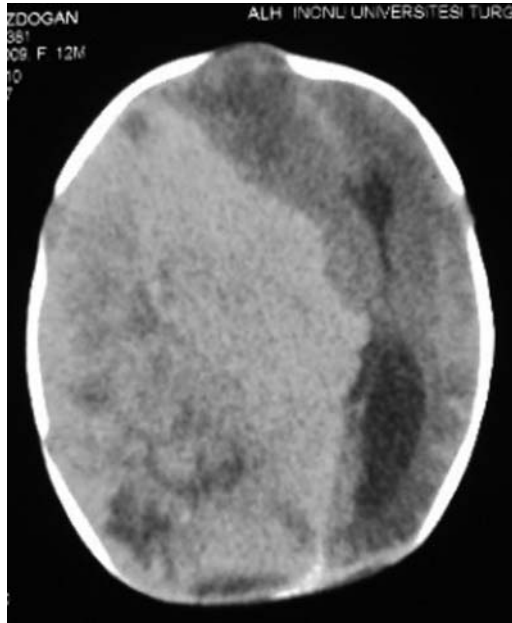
Head CT showing a very large tumor in the right cerebral hemisphere with significant mass effect.
